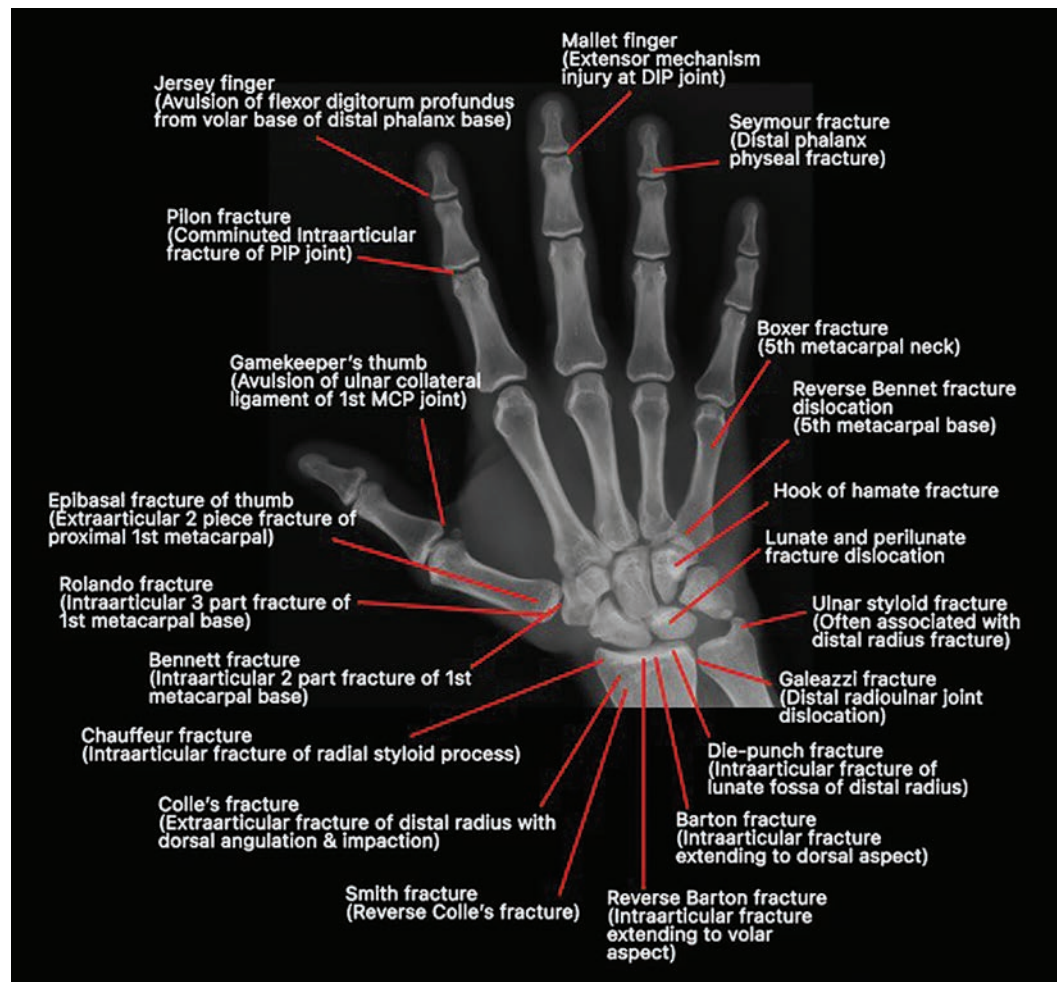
Eponymous fractures in hand radiograph
